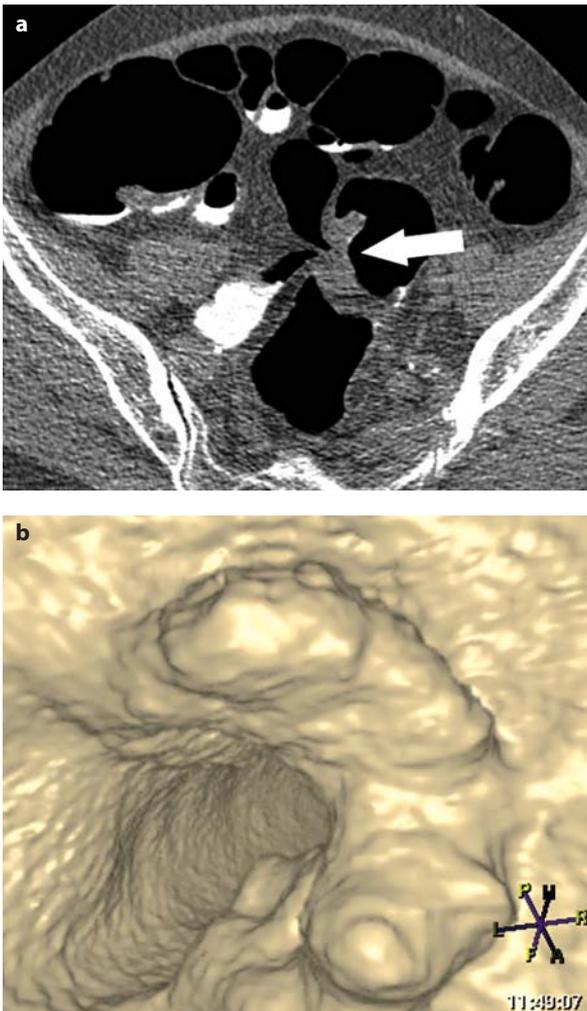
a, b. Patient with colorectal cancer. CT colonography with the patient in the supine position after extensive bowel preparation and fluid tagging demonstrates the cancer (*arrow*) in the rectosigmoid at 2D (a) and 3D (b) evaluation
